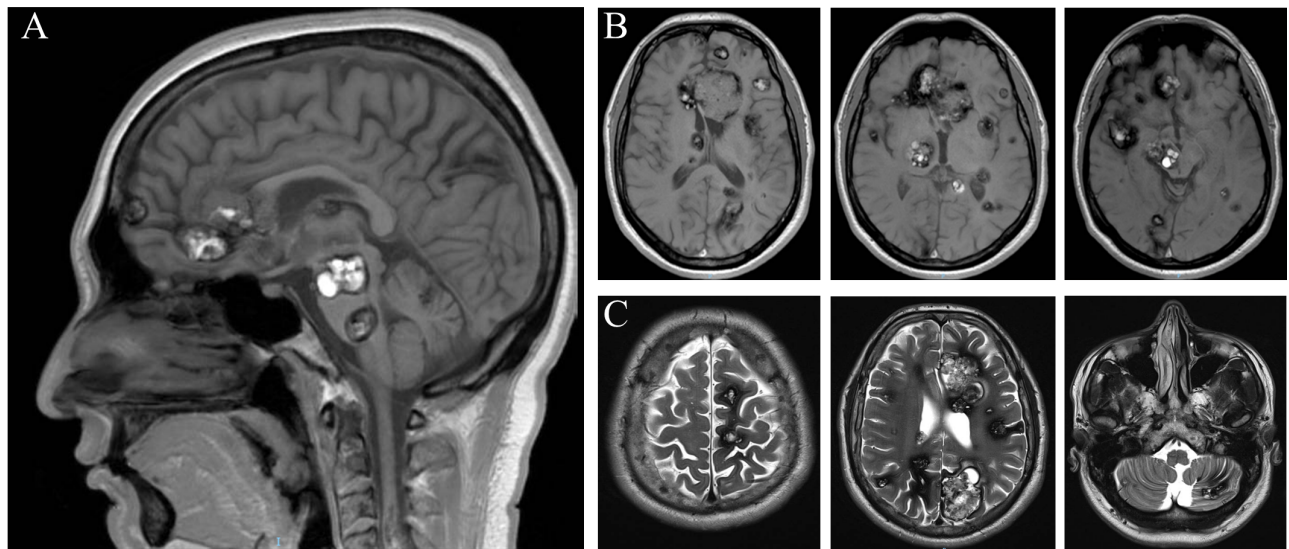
MRI. Sagittal T1 (A) and axial T1 (B) and T2 (C) images that show multiple cavernomas in both supratentorial and infratentorial territories, including the brainstem, with mass effect.
